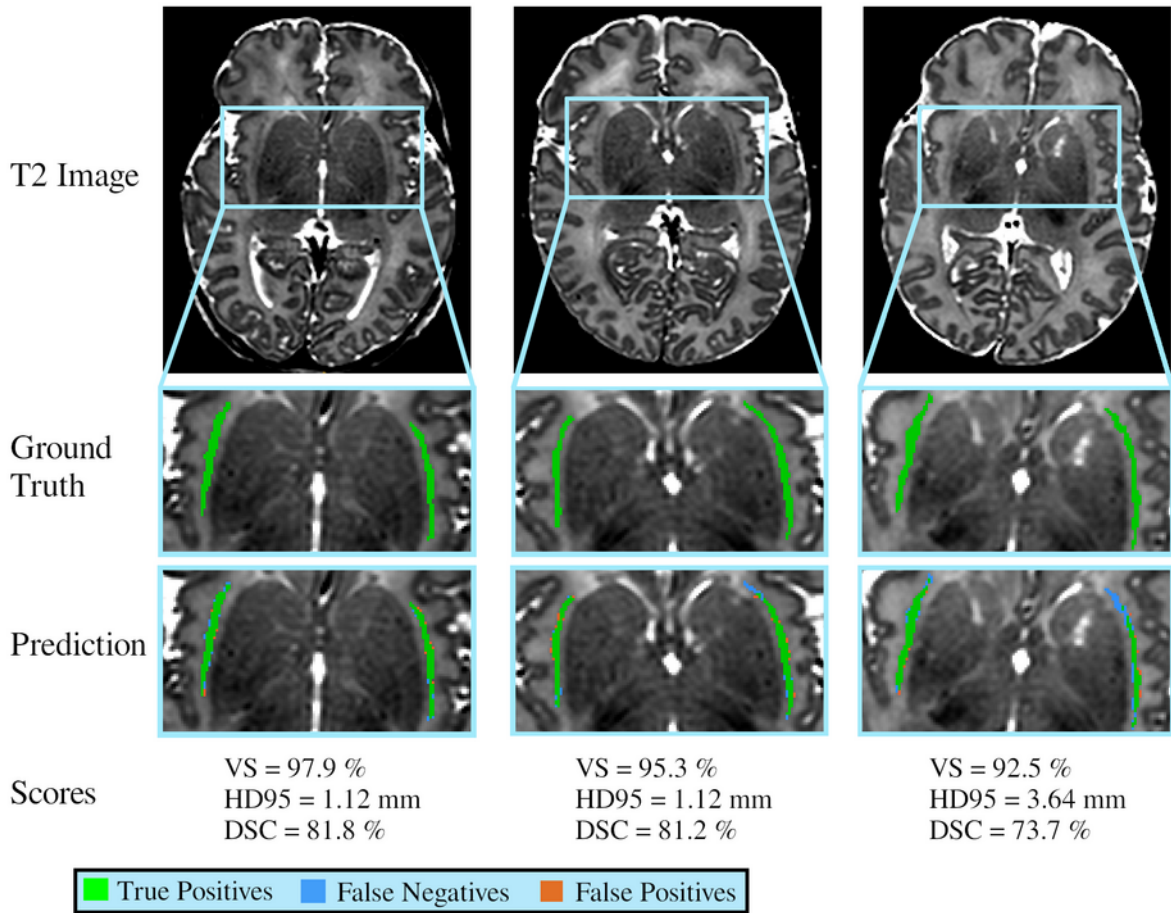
Three examples of the claustrum segmentation in neonatal T2-weighted brain MRI.
